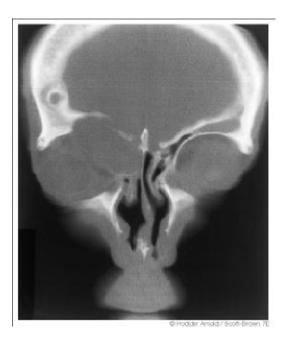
CT scan in a patient with frontoethmoid mucocele showing expansile lesion in right frontal sinus with bony erosion of the floor of the frontal sinus
